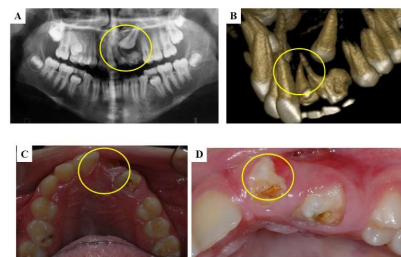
Traumatic dilaceration, displacement, and root resorption of the maxillary anterior teeth. (A) Panoramic radiograph showing post-traumatic developmental disturbances, including dilaceration of teeth 21 and 22 and displacement of tooth 23. (B) Three-dimensional CBCT reconstruction confirming the abnormal position and morphology of the affected teeth. (C) Intraoral occlusal view of the impacted and displaced teeth. (D) Magnified intraoral view showing malformed crown morphology, eruption disturbance, and external root resorption of tooth 21. Circled areas indicate trauma-related changes.
